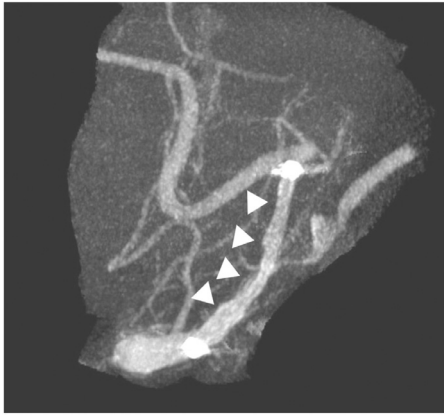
Cone-beam CT after stent placement. The stent was placed in the vertebral artery from the posterior inferior cerebellar artery, and straightening of the stent placement was observed (arrow heads). CT, computed tomography.
